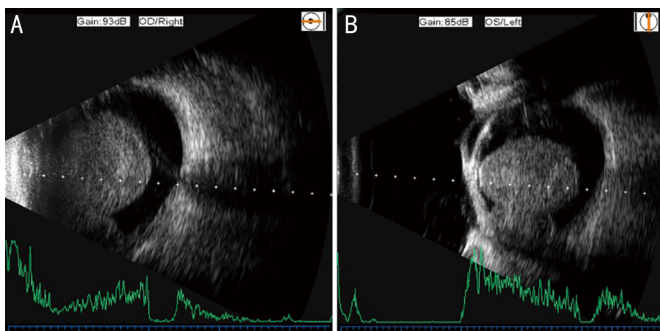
Incomplete observation case of choroid tumor A: Incomplete conventional B-ultrasound observation; B: Complete observation by Pano-immersion B-scan ultrasonography.
